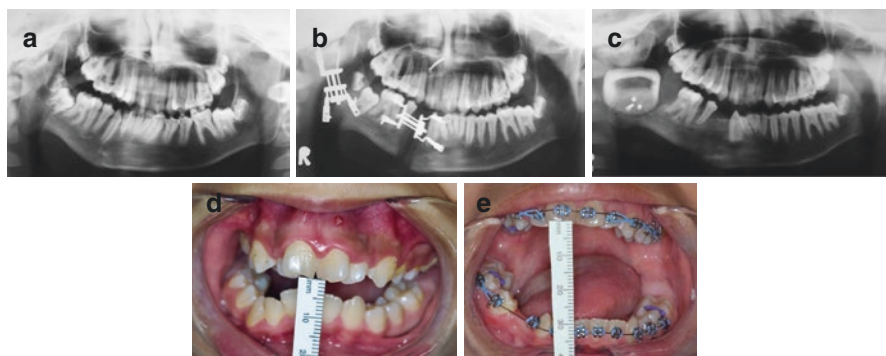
Same patient as in Fig. 5.7. (a) Panoramic radiograph preoperative. Note the unilateral TMJ ankylosis. (b) Panoramic radiograph following activation of ramus and body distraction devices. (c) Panoramic radiograph showing TMJ implant. (d) Intraoral view preoperative. (e) Intraoral view postoperative. Note the increase in interincisal opening
